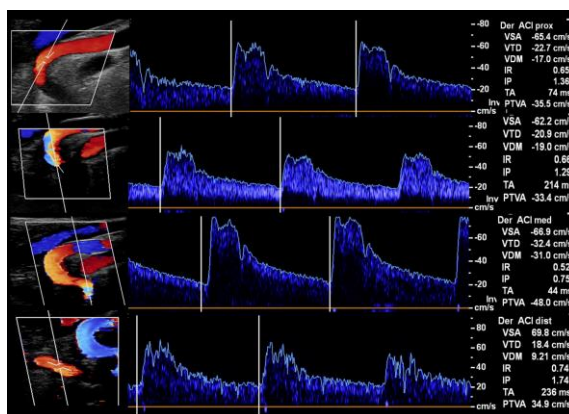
80-years old men with a history of transient cerebral ischemia. ICA with color and pulsed Doppler application. Evaluation in 4 segments of the ICA where PS velocities not greater than 69.8 cm / s are observed, with variability not greater than 7.6 cm / s. As in the previous example, there are certain cases in which, despite the angled segments, no significant variability is observed in the velocities of the assessed paths.
